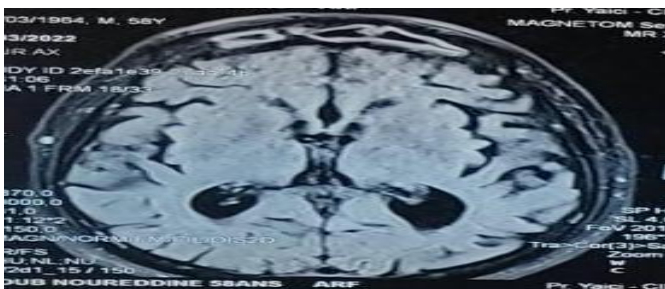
Brain MRI (Axial FLAIR image):
